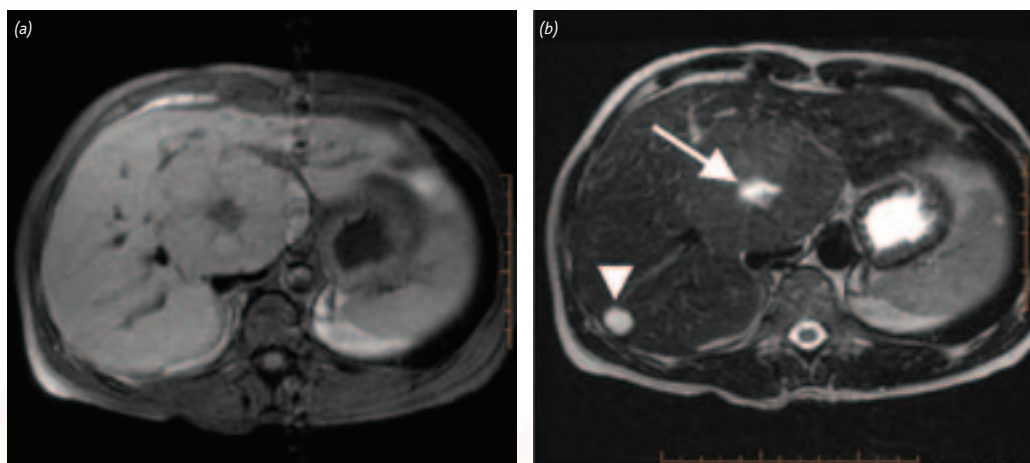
Focal nodular hyperplasia in a young woman. The tumour is isointense with the normal liver parenchyma except for the central scar (long arrow) which is (a) hypointense on the T1-weighted MRI image and (b) bright on the T2-weighted image. Incidentally there is a bright lesion on the right liver lobe corresponding to a small haemangioma (short arrow)
